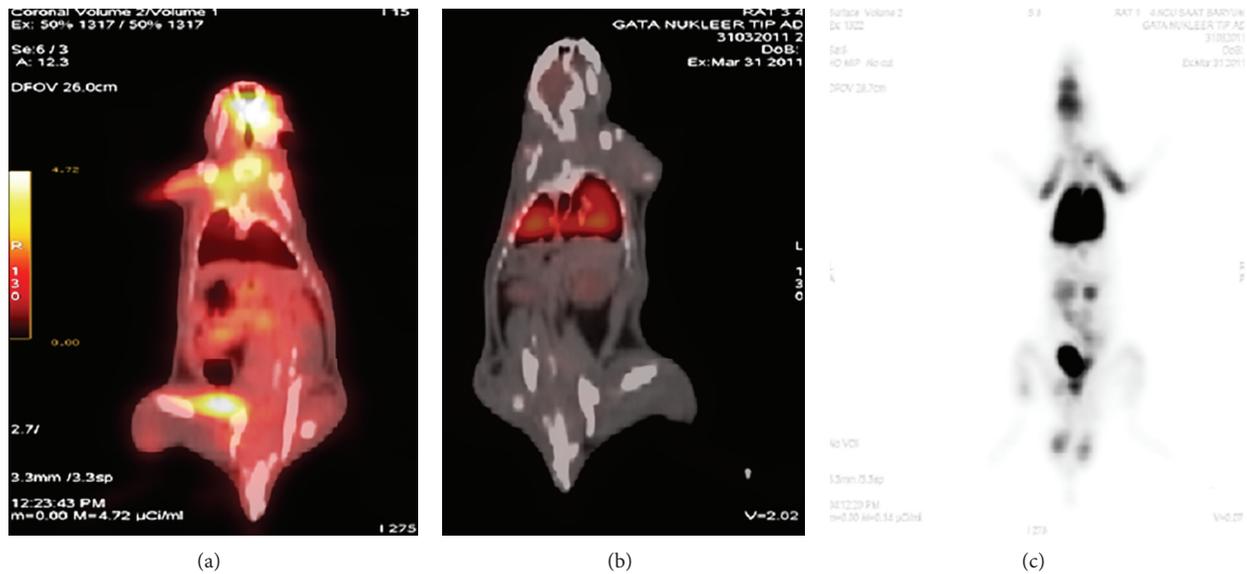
PET/CT image demonstrated the altered biodistribution between FDG (a) and the labeled stem cells with FDG (b). Prominent accumulation of the labeled stem cells in the lung was demonstrated by PET/CT (B) and PET image (c).
